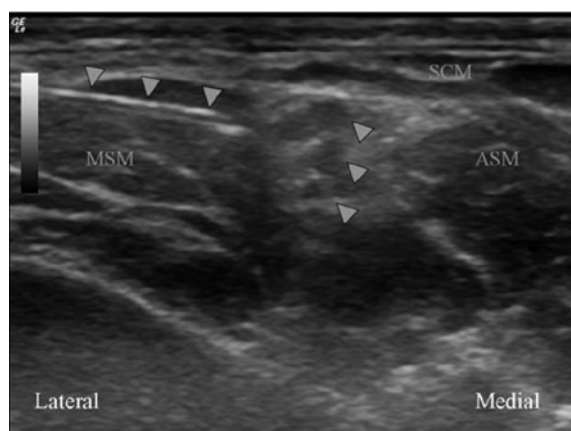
Ultrasound-guided interscalene block.
